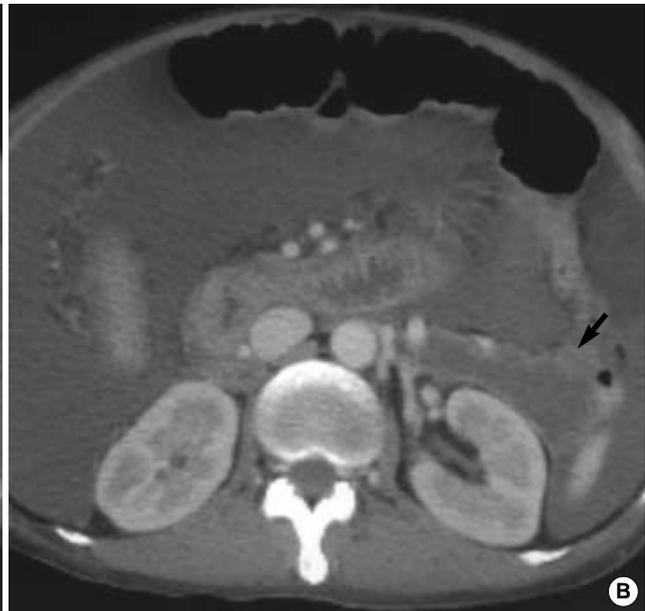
(A) Contrast-enhanced computed tomography showing an edematous pancreas with dilated pancreatic duct. (B) Loculated fluid at left anterior perirenal space with massive ascites was noted (arrow).
